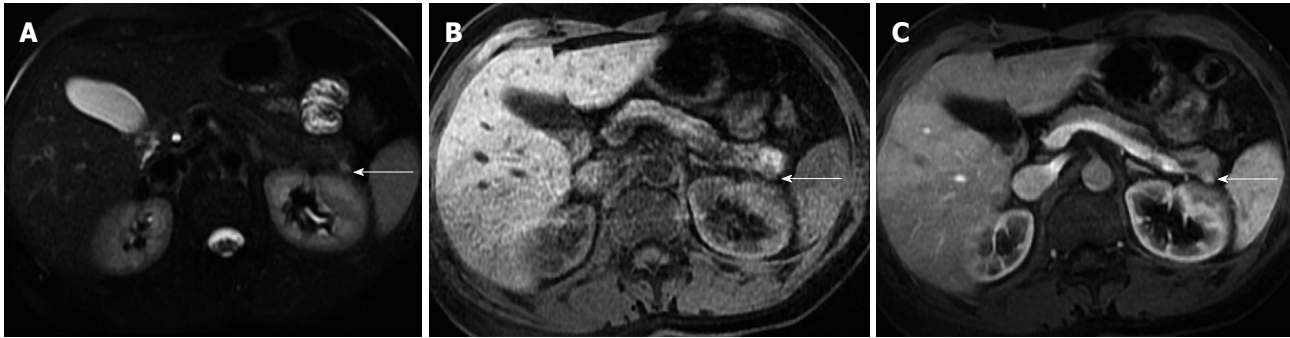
Pancreatic neuroendocrine tumor. Axial fat-suppressed T2-weighted SS-ETSE (A), pre-contrast fat-suppressed T1-weighted (B) GRE and arterial phase fat-suppressed T1-weighted GRE image (C). There is a small solid lesion in the tail of the pancreas (arrow, A-C), showing moderate signal intensity on T2-weighted images (arrow, A) and demonstrates marked enhancement in the arterial phase of enhancement (arrow, C). This was an insulinoma. SS-ETSE: Single-shot echo train spin echo; GRE: Gradient echo.
